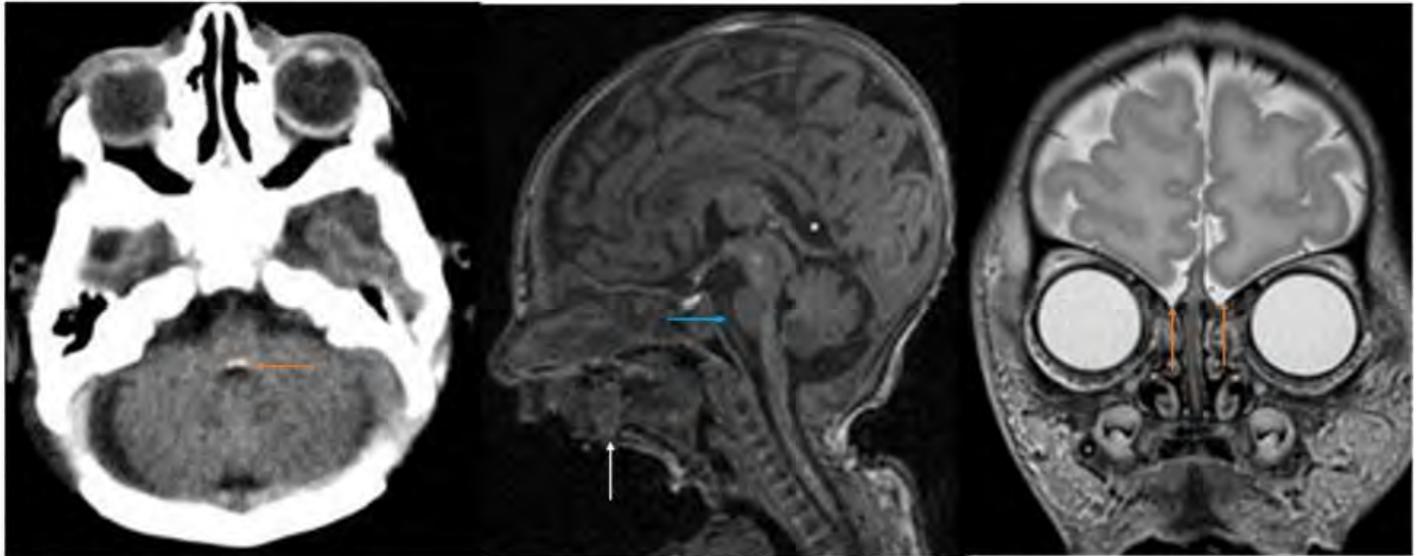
Axial Non contrast CT demonstrates dorsal Brainstem Calcification (brown arrow)
